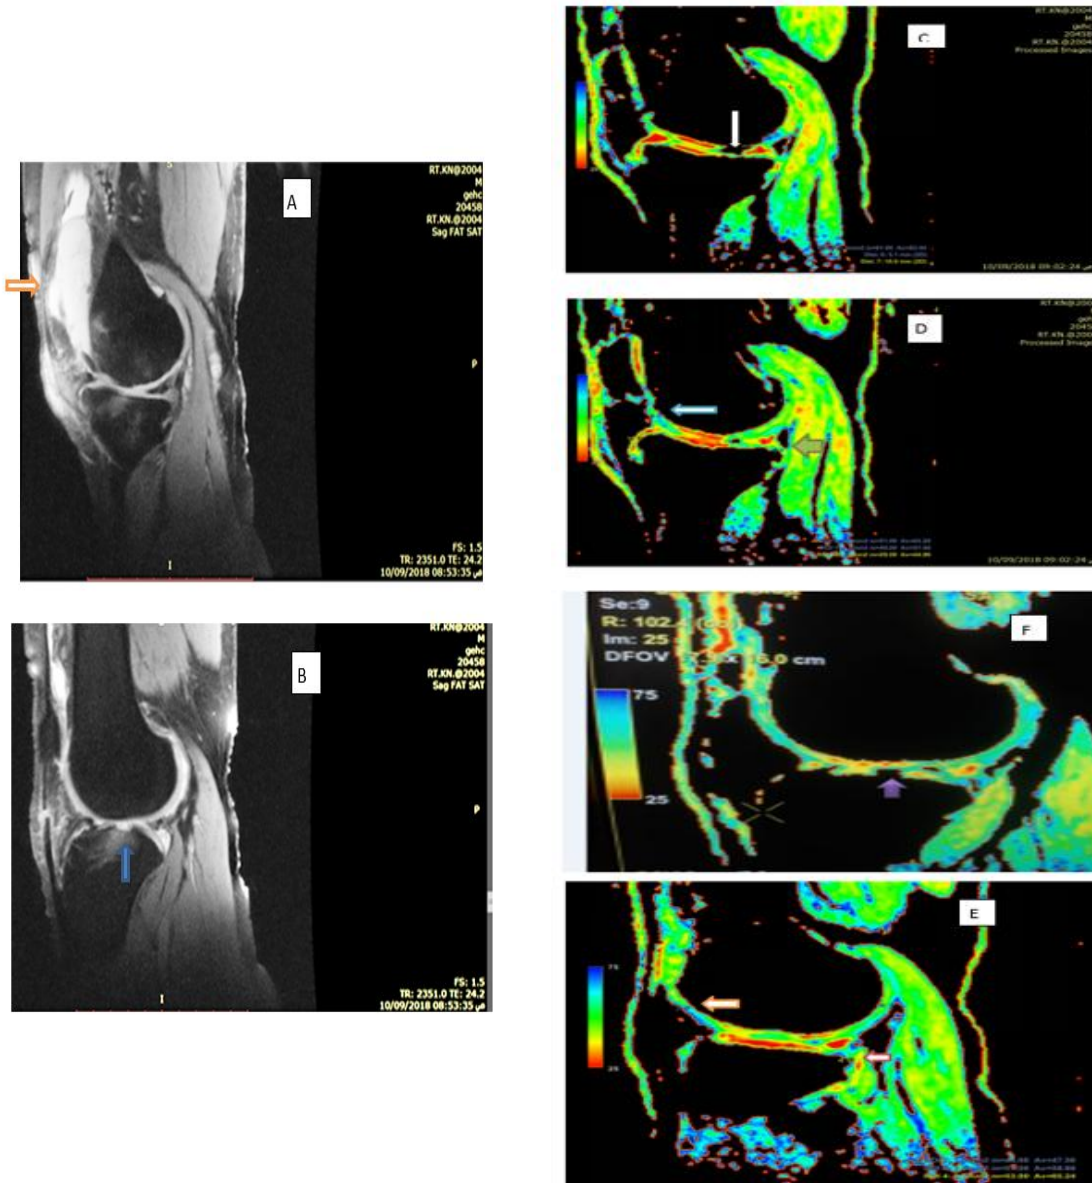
(A,B) Conventional MRI, sagittal fat sat at medial (A) and lateral (B) tibiofemoral condyles :Show increased signal intensity of cartilage covering the medial tibiofemoral condyle with decreased cartilage thickness and irregularity at the cartilage fullthickness cartilage lesion at the lateral tibial condyle "cartilage ulcer" (blue arrow). Knee joint synovial effusion with supra pateller plica (orange arrow). (C,D,E,F) sagittal T2 mapping at medial (C,D) and lateral (E,F) tibiofemoral condyles: Show elevated color coded values of cartilage at media tibio femoral condyle . Elevated color coded values of cartilage at lateral tibio femoral condyle. Full thickness cartilage lesion at the medial femoral condyle "cartilage ulcer" measure (10mm)(white arrow) this ulcer appear also by arthroscopy.Full thickness cartilage lesion at the lateral tibial condyle "cartilage ulcer" (purple arrow)this ulcer appear also by Conventional MRI, sagittal fat sat sequence
